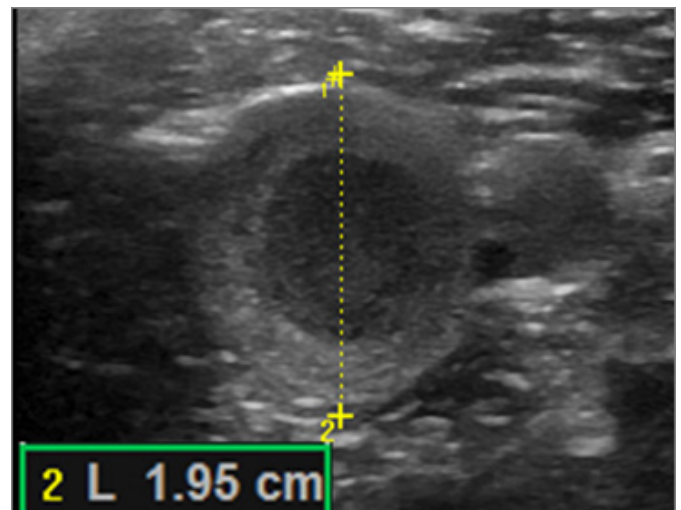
Duplex ultrasound scanning: donaut sign
